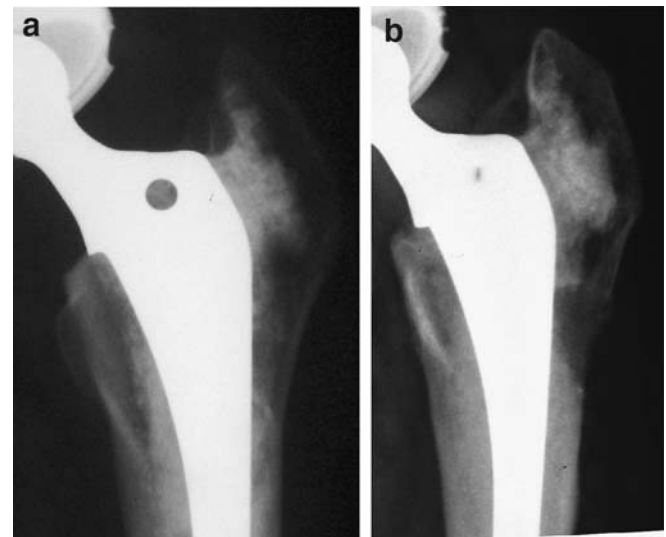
a Postoperative radiograph of a total hip arthroplasty with the VerSys CT stem after a failed core decompression for osteonecrosis of the femoral head. b Eight years later, osteolysis developed at the site of the lateral femoral opening. The stem remains well fixed
